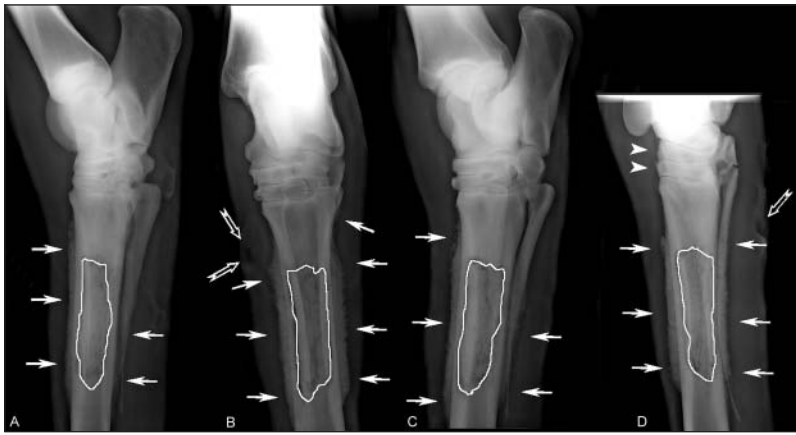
Same radiographic images as in Figure 1. A 12-cm-long bone fragment is sequestered within the third metatarsal bone (white line). A palisading periosteal reaction is visible (white arrows) as well as a focal gas opacity representing the cutaneous wound (open white arrows) on the proximomedial aspect of the metatarsal region. Notice the periosteal reaction present on the dorsolateral aspect of the central and third tarsal bones (white arrowheads).
